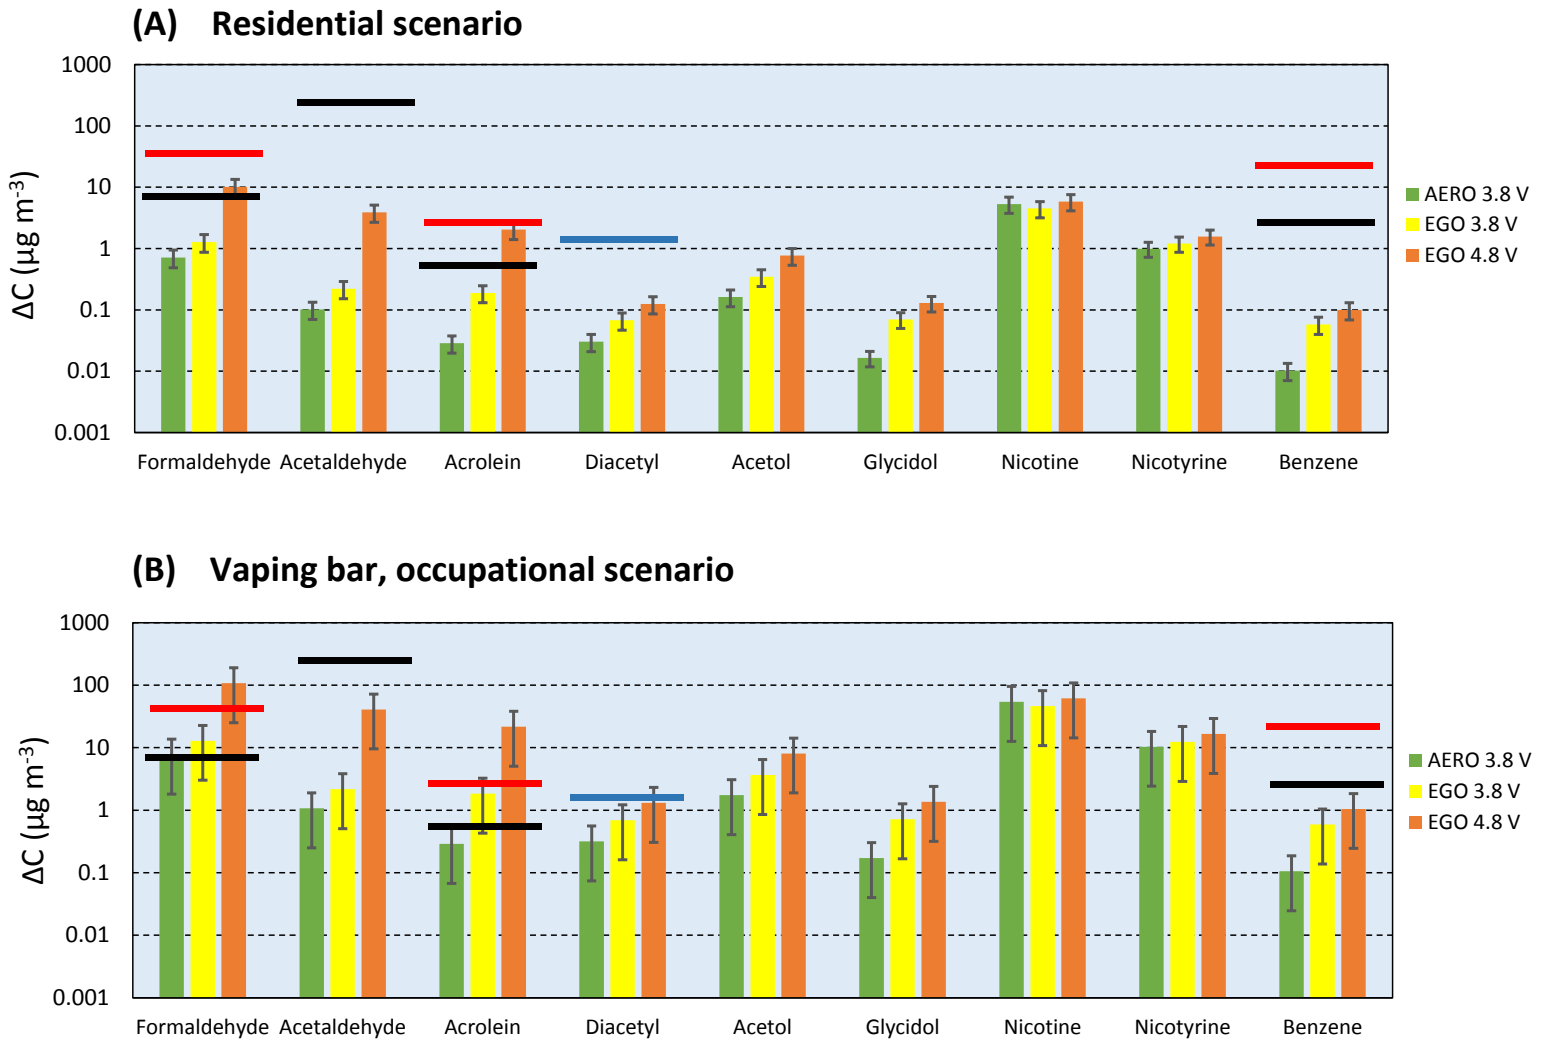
Change in average indoor air VOC concentrations for (A) a residential scenario in which the vaper stays at home most of the time, corresponding to an elevated usage rate of 250 puffs per day, and (B) a bar that allows vaping. Three different device/voltage combinations using the CT e-liquid were used to determine emission rates for typical puffing sessions of 25 puffs each. Black and red lines represent California OEHHA Reference Exposure Levels for 8-h and 1-h exposures, respectively, for formaldehyde, acetaldehyde, acrolein and benzene. The blue line represents the NIOSH recommended 40-h workweek exposure limit for diacetyl.
